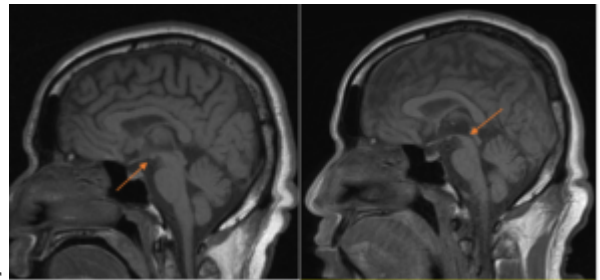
MRI, T-1 weighted images, sagittal view. Left: Initial study three years prior with robust midbrain. Right: Most recent study demonstrating significant midbrain atrophy. [Click to enlarge](#)
